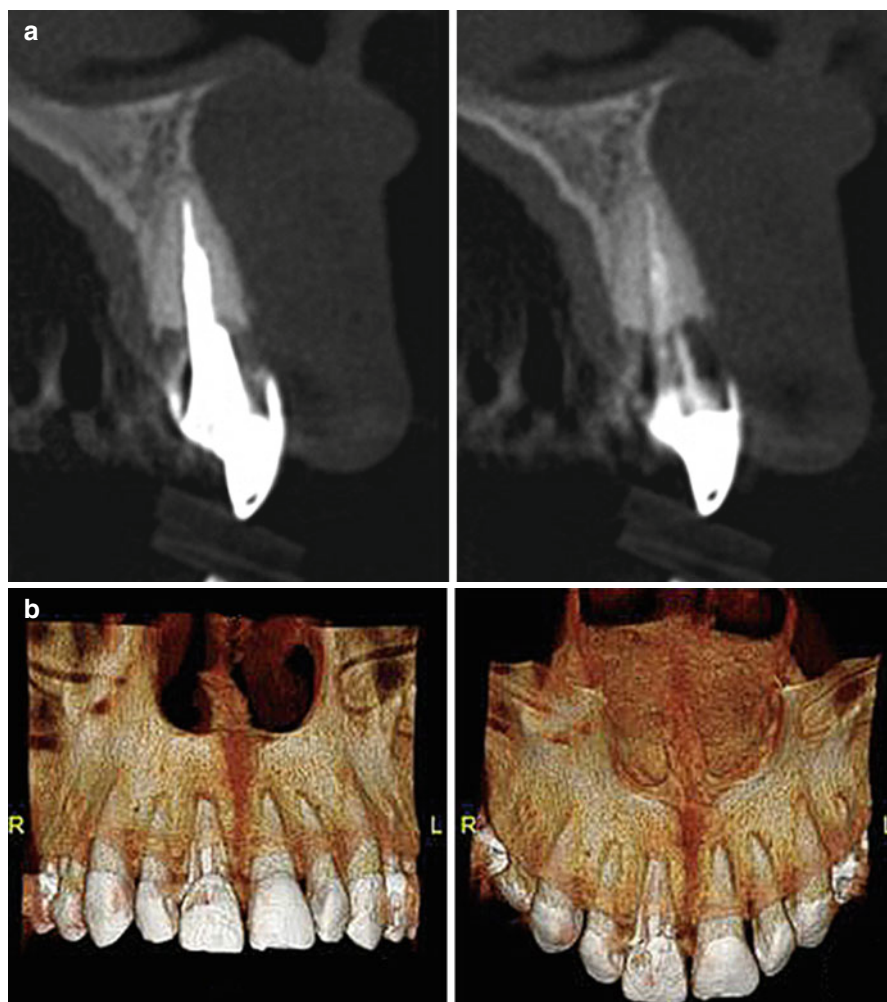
Cone-beam computed tomography (a) with reconstructed three-dimensional (3D) image (b) showing an ECR lesion on tooth #8 (FDI 1.1). This tooth had been treated with intracoronal whitening in two different occasions, but did not respond to the treatment. The ECR lesion was diagnosed after the tooth was restored with a cast post-and-core and a full-coverage restoration (Images courtesy of Prof. Eduardo Vilain de Melo, Florianópolis, Brazil)
